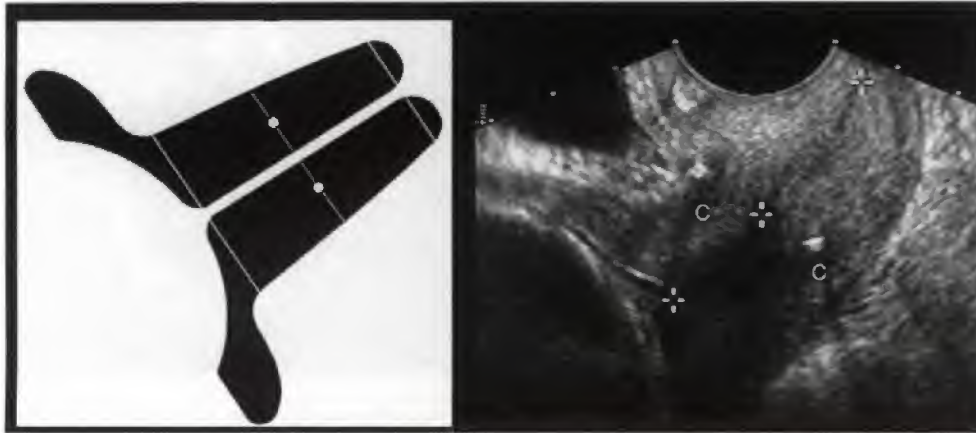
Sonogram in a patient with cervical funneling. Typically funnel width is measured by identifying the lower uterine segment notch (or genu) either anteriorly or posteriorly (or both), and a line perpendicular to the axis of the cervical canal connects to the opposite side. The funnel length is measured by connecting the middle of the funnel width with the tip of the funnel. Cervical length is measured from the tip of the funnel to external os.
